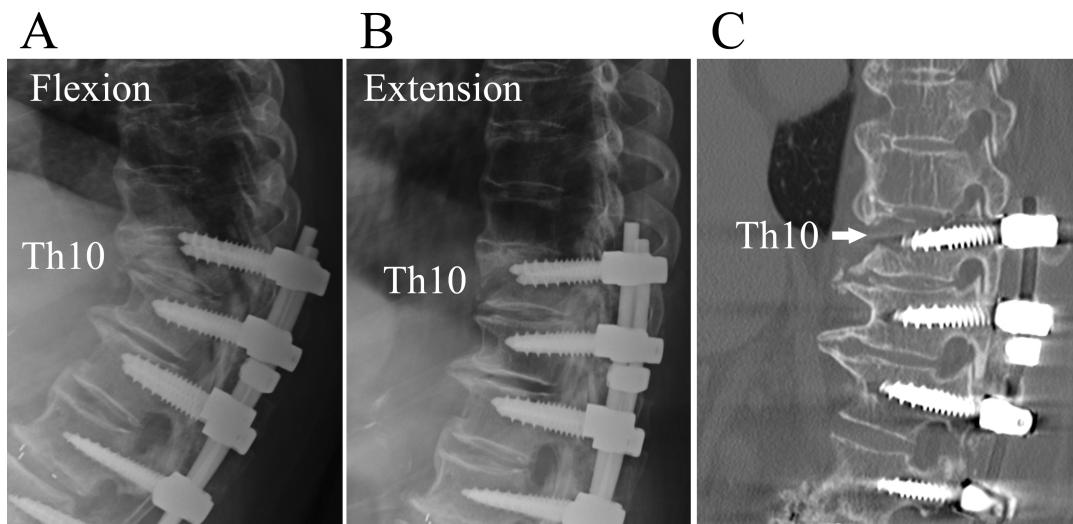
A and B, Flexion-extension radiographs of the thoracic spine demonstrating junctional fracture of Th10 and adjacent subluxation of Th9. C, Sagittal reconstructed computed tomographic scan revealing junctional fracture through the anterior superior body and superior endplate of Th10 (arrow).
